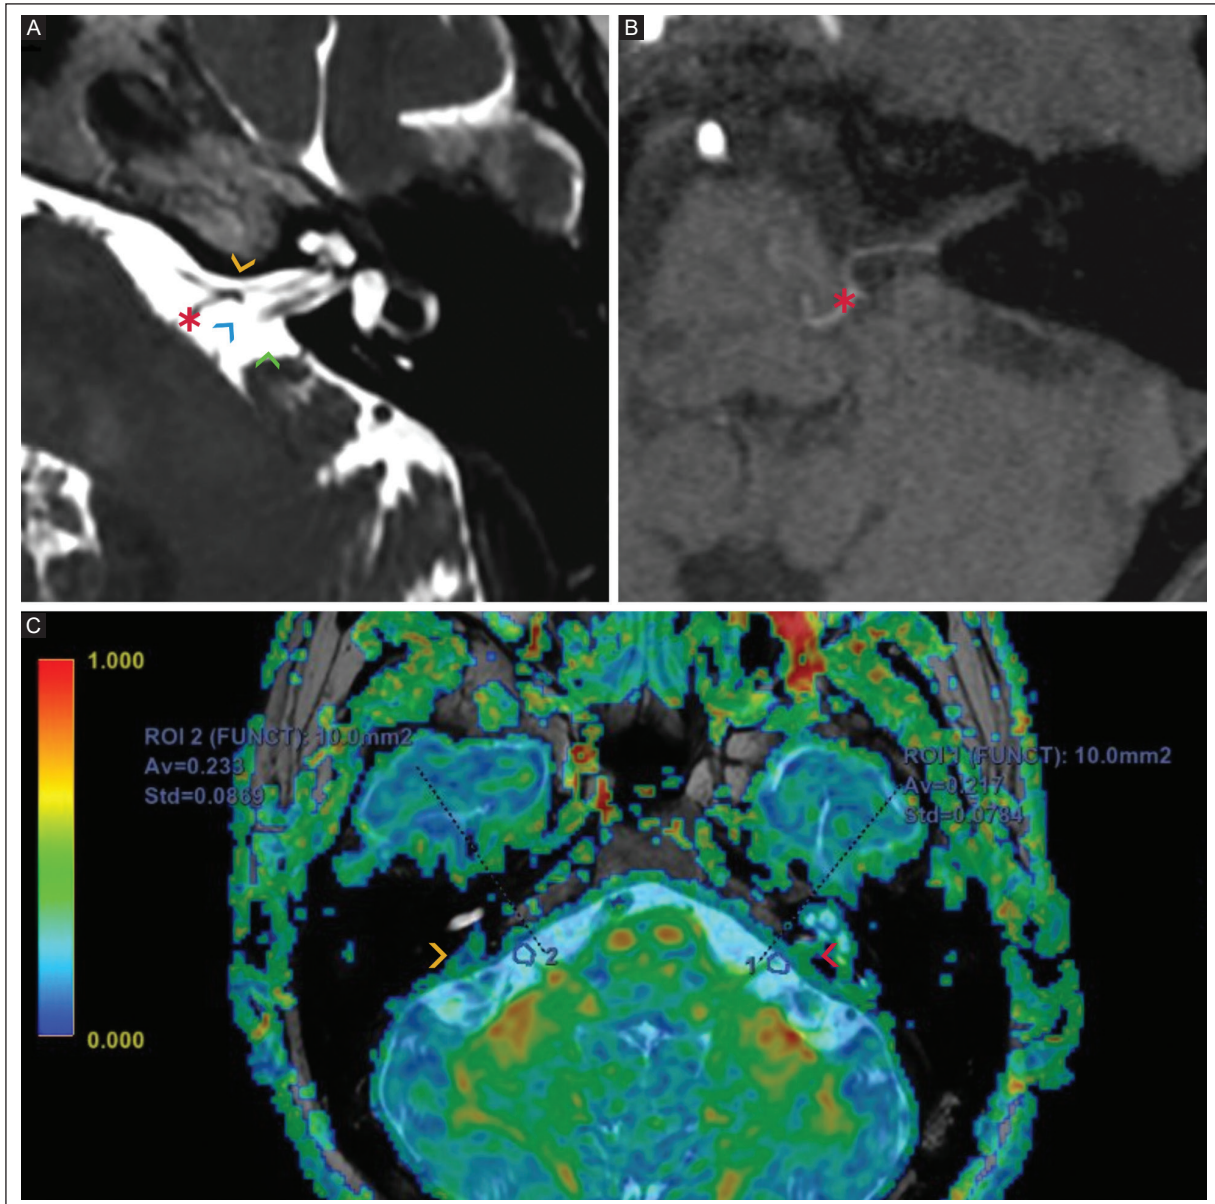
A 3.0T MRI of a 58-year-old man with tinnitus and vertigo. A: T2-weighted CUBE shows NVC Chavda type I and Gorrie grade C (yellow arrowhead) on the left side in the cerebellopontine angle (green arrowhead). B: the 3D-TOF demonstrates the vascular loop (asterisk) in the cerebellopontine angle. C: a DTI T2-weighted CUBE fusion shows decreased FA of 0.217 in the ROI at the level of the NVC (red arrowhead). The contralateral ear shows FA of 0.233 (yellow arrowhead).
